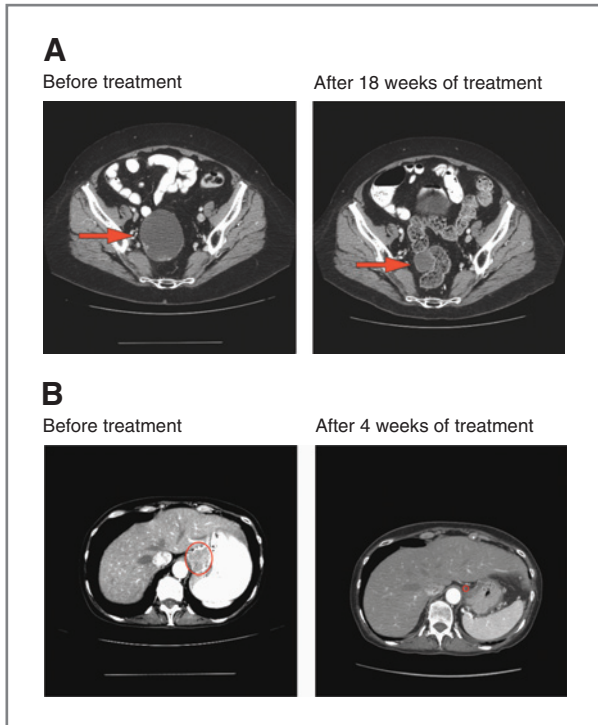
Computed tomography scans of responding patients. A, patient with endometrial cancer demonstrating partial response in pelvic mass. B, patient with squamous cell cervical cancer demonstrating partial response in gastrohepatic metastasis. Arrows or circles, locations of metastases
